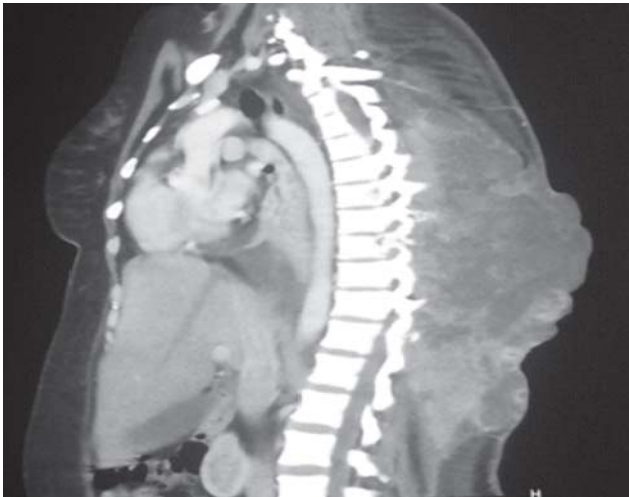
Computed tomography of chest (1 midline sagittal section) showing craniocaudal extent of the tumour.
